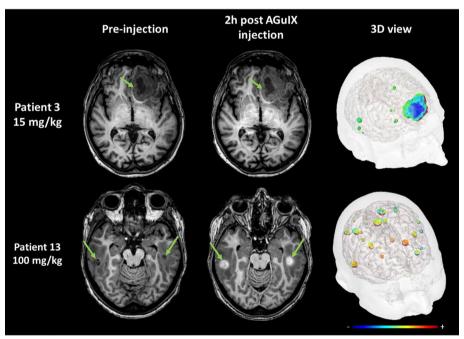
T1-weighted MRI scans (3 T field strength) for 2 patients in the NANORAD-1 trial, taken prior to injection of AGuIX (left) and 2 h later (right) (green arrows point to metastatic tumour deposits), that demonstrate AGuIX accumulation post-injection via T1 contrast enhancement, most visible for the higher dose case. The 3D view demonstrates digital reconstruction of contrast uptake (colour bar) (Reprinted with permission from Verry et al. (2021), copyright 2021, Elsevier)
